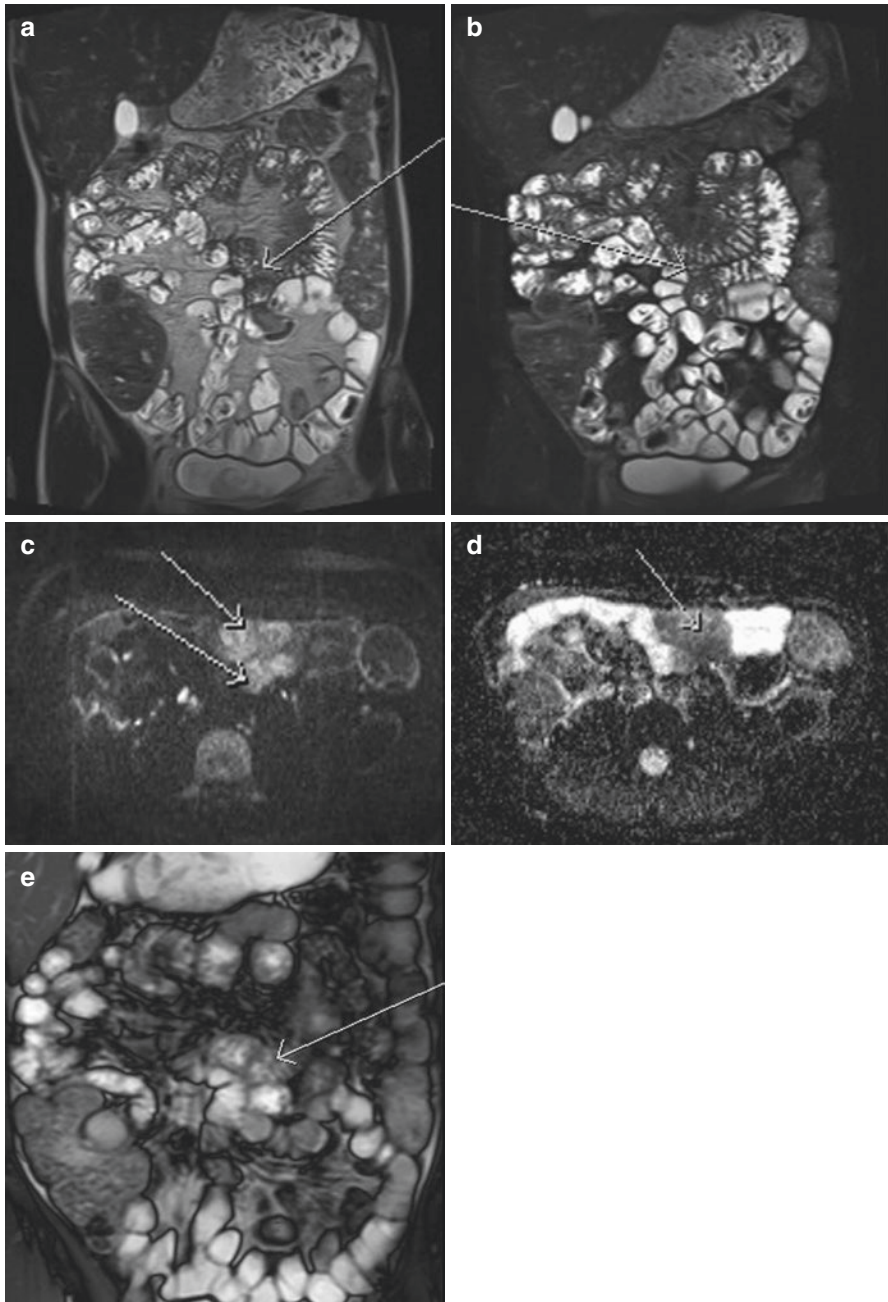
False positive DWI, a common finding in under distended bowel, particularly in the jejunum (*arrows*), as seen on (a) coronal HASTE and with fat saturation (b). Apparent restricted diffusion as demonstrated on the DWI and corresponding ADC map ($B = 600 \text{ s/mm}^2$) (c, d), but Cine Trufi T2 (e) sequence slabs show normal motility and distension of the corresponding bowel
